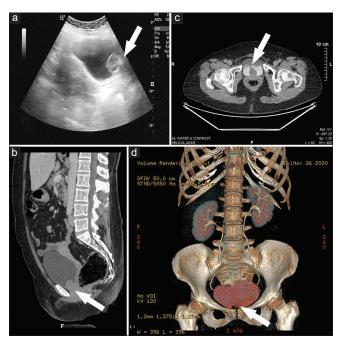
Imaging evaluation of the patient. (a) Ultrasonographic image identifying the solid mass at the bladder neck. (b) Coronal plane of the computed tomography scan demonstrating the urethral involvement. (c) Axial plane of the computed tomography urography showing the characteristic filling deficit into the bladder (white arrow). (d) Threedimensional reconstruction of the urinary tract demonstrating a deficit (white arrow) at the level of the pubic symphysis
